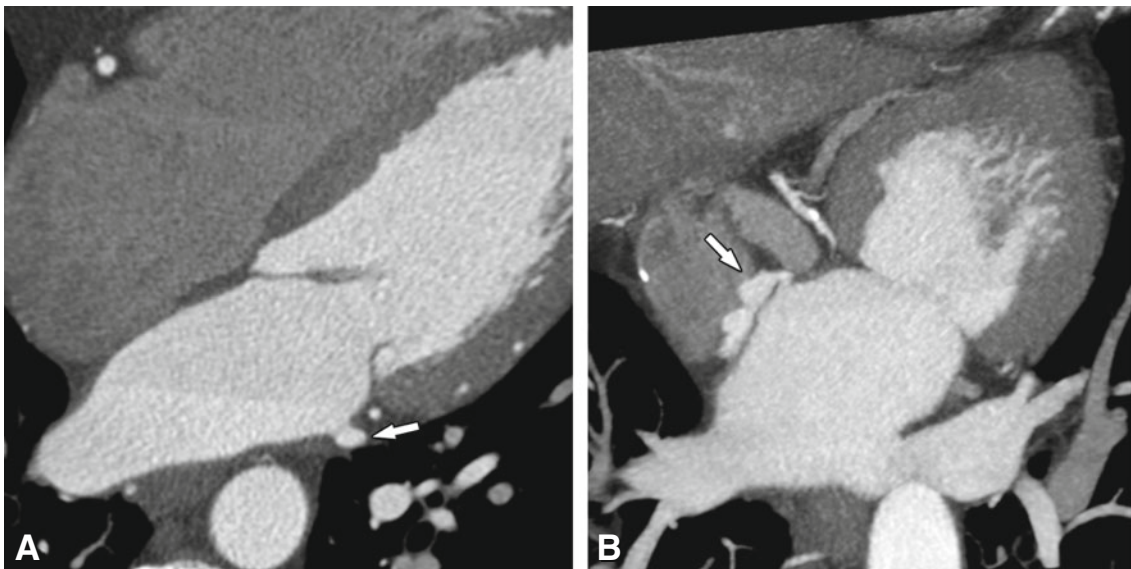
Contrast-enhanced CT in four-chamber view (Panel A) and oblique maximum intensity projection (Panel B) in two different patients with atrial fibrillation referred for preprocedural anatomy evaluation. Atrial diverticula along the left (*arrow* in Panel A) and right atrial wall (*arrow* in Panel B) are seen. Small diverticula as in Panel A are of no clinical significance. However, thrombus formation in large diverticula, although rare, has been described. The presence and location of diverticula must be reported, as they constitute potential sites of catheter entrapment. Diverticula could give rise to thrombus formation or perforation, since their walls are much thinner than that of the adjacent normal atrium. In practice, atrial diverticula are commonly seen and generally do not cause significant problems during RF ablation procedures
